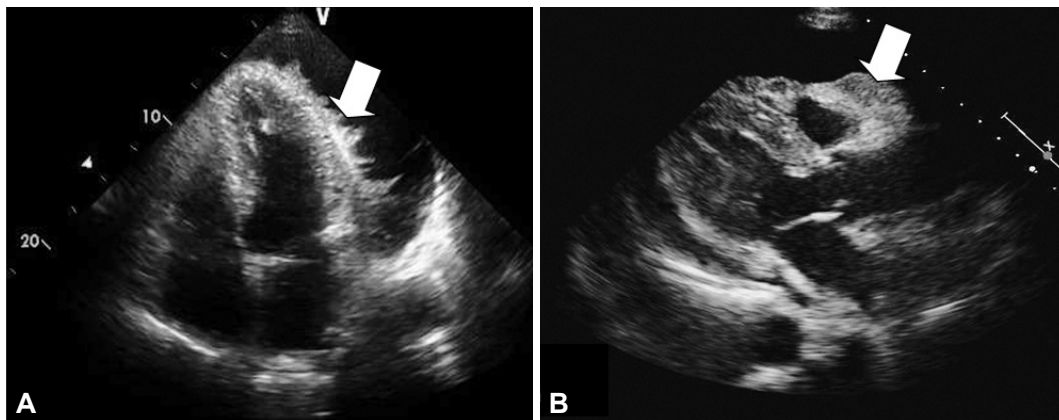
Echocardiography showing abnormal masses on the epicardial surface. Final diagnoses are (A) post-operative pericarditis and (B) metastatic infiltration of lung cancer to pericardium.
